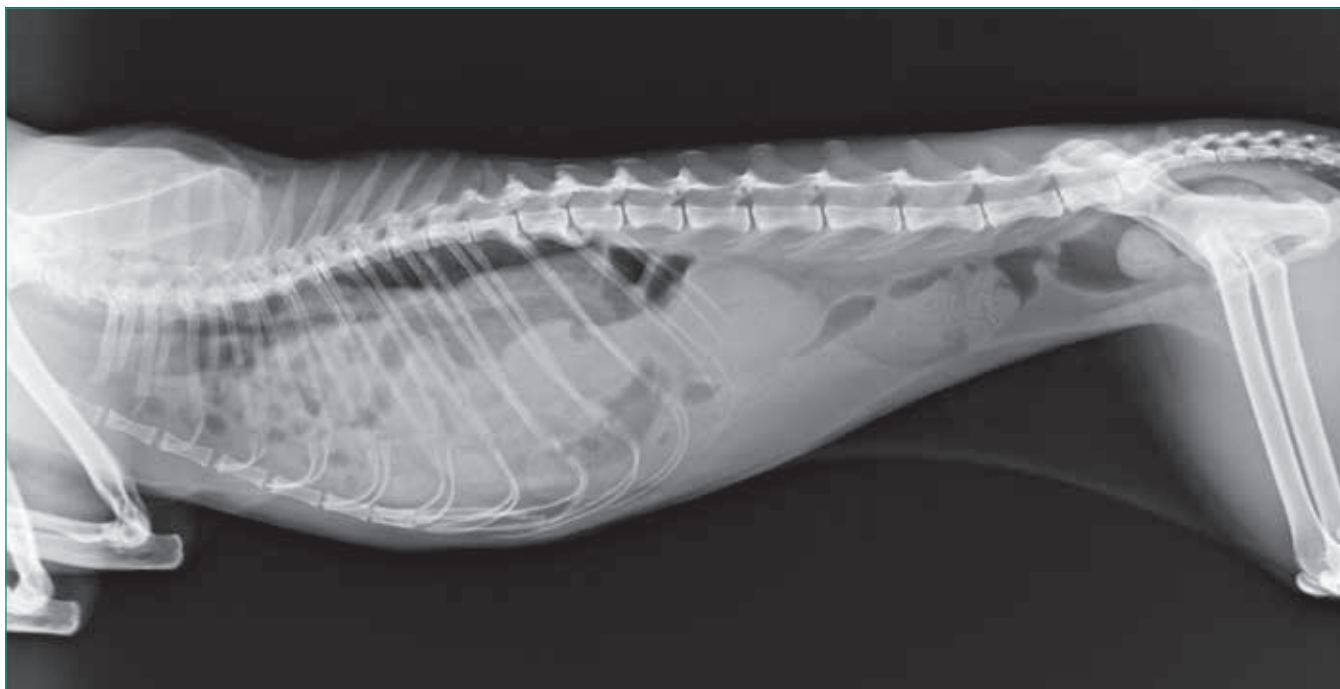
X-ray of a patient with peritoneopericardial diaphragmatic hernia. The liver, intestine, and part of the stomach are present in the hernial sac.
